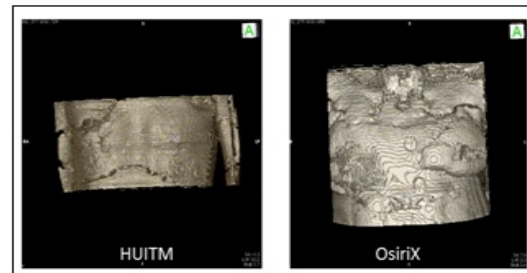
Three-dimensional model developed from hospital UITM and OsiriX MRI slices
